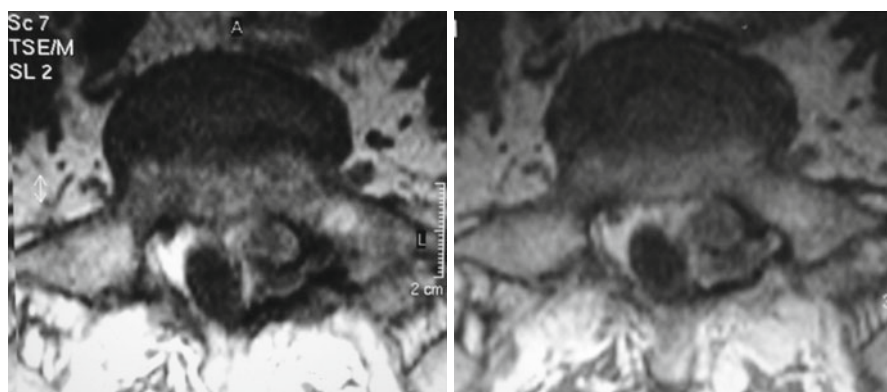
Preoperative MRI. Comparison of axial T1-weighted images before (a) and after (b) gadolinium injection. The left L5–S1 heterogeneously hyperintense cystic lesion, compressing the cauda, shows a moderate increase of the signal after the contrast injection, particularly around the edges of the lesion. Diagnosis was lumbar hemorrhagic synovial cyst
